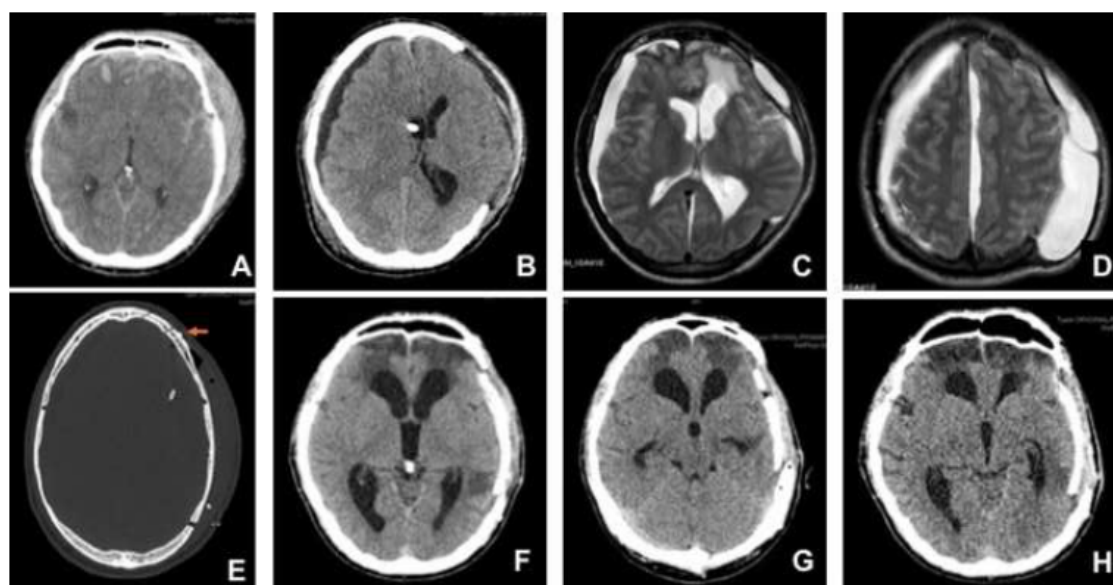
(A) CT scan performed five hours after admission showing small bifrontal contusions, subarachnoid hemorrhage, a small left subdural hematoma and diffuse edema. (B) Follow-up CT scan performed 2 weeks postoperatively and after ventricular catheter closure prior to its removal. A right subdural hygroma with mass effect is evidenced, and a left subcutaneous collection can be appreciated too. (C, D) Follow-up MRI performed 1 month postoperatively, showing right and interhemispheric hygromas, as well as increased size of the left CSF hygroma. (E) Postoperative CT scan performed 24 hours after bone flap replacement. 4-mm screws and miniplates were used to fix the implant (arrow) (F) Postoperative CT scan 2 months after bone flap replacement. (G) 6-month follow-up CT scan, showing slight sinking bone flap in absence of symptoms. (H) 1-year follow-up CT scan, showing significant sinking bone flap when symptoms were evident.
